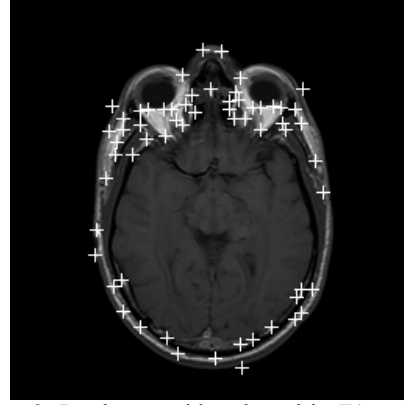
Patch centroids selected in T1-weighted MRI cranial slice used as gold standard
